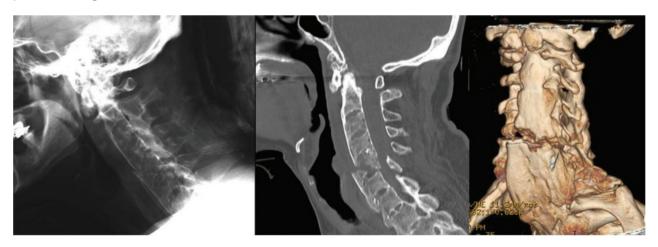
Ankylosing spondylitis A cervical spine fracture involving the C5–C6 level in a patient with AS. Note the low definition of X-ray to define the fracture on the left, further clarified by a CT scan that shows the instability pattern of this severe injury. Note also the fusion pattern affecting the multiple cervical segments.
